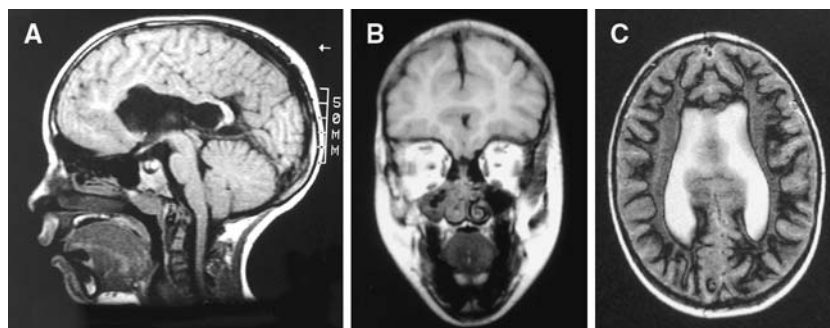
T1-weighted magnetic resonance imaging (MRI) of the cerebrum at 6 years of age. The sagittal T1-weighted image (a) shows the absence of the anterior part of the corpus callosum, characteristic of holoprosencephaly (HPE). Note that the frontal lobes are fused. The coronal T1-weighted image (b) and axial
